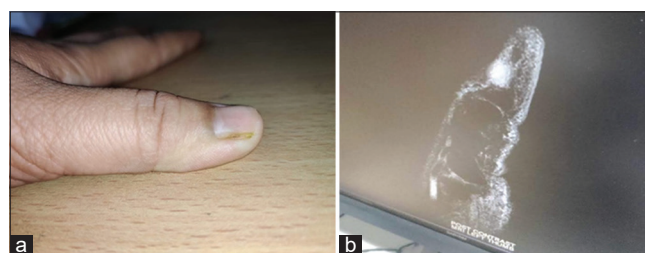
Subungual location of glomus tumor. (a) Clinical picture preoperative. (b) Magnetic resonance imaging showing soft-tissue lesion in subungual area
